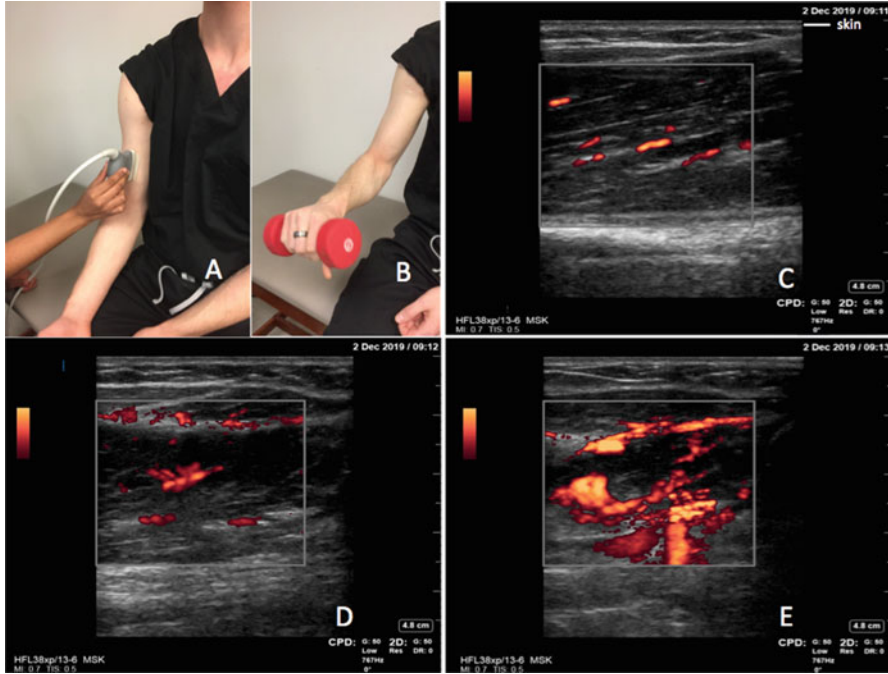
The position of the transducer used to acquire a longitudinal view of the biceps brachii muscle is shown in (a). In (b) the forearm is shown while completing a cycle of supination-pronation with the hand holding a 5 lb. weight. Combined gray scale—power Doppler images of the biceps brachii muscle (long view) at rest (c), and after 25 (d) and 50 (e) cycles of pronation and supination
